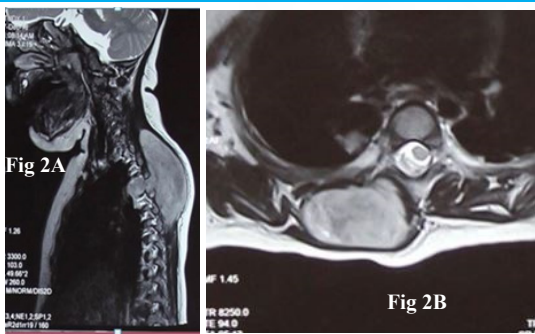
T2 MRI of Dorsal spine (Figure 2A Sagittal view, Figure 2B axial view) which shows heterogeneous intensity.
